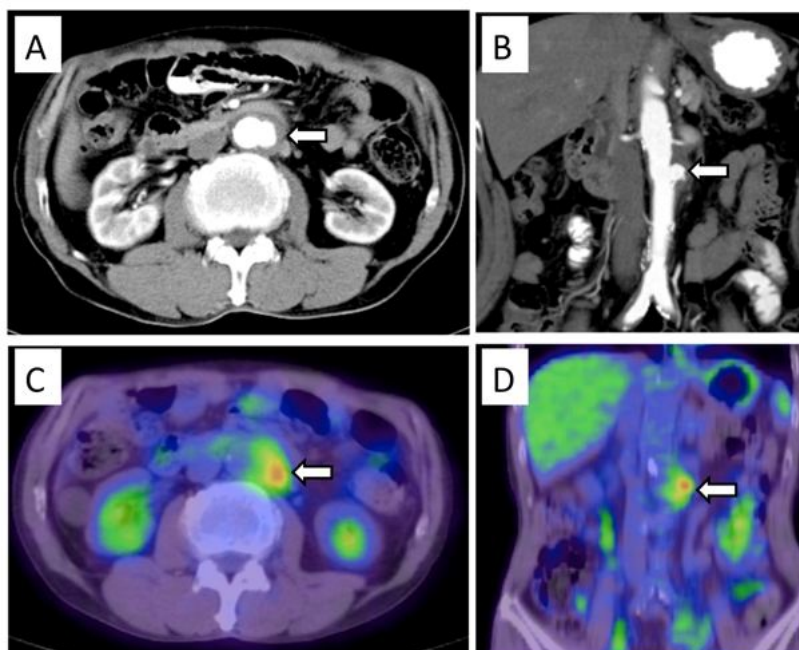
Images of contrast-enhanced computed tomography (CT) and fluorodeoxyglucose-positron emission tomography (FDG-PET)/CT. A and B, Axial and coronal CT images of the infrarenal aorta revealing a sacular aneurysm (arrows). C and D, Axial and coronal FDG-PET/CT images revealing abnormal FDG hypermetabolism with maximum standard uptake value (SUVmax) of 6.2 in the abdominal aorta wall and periaortic space (arrows). (Modified from [18])
